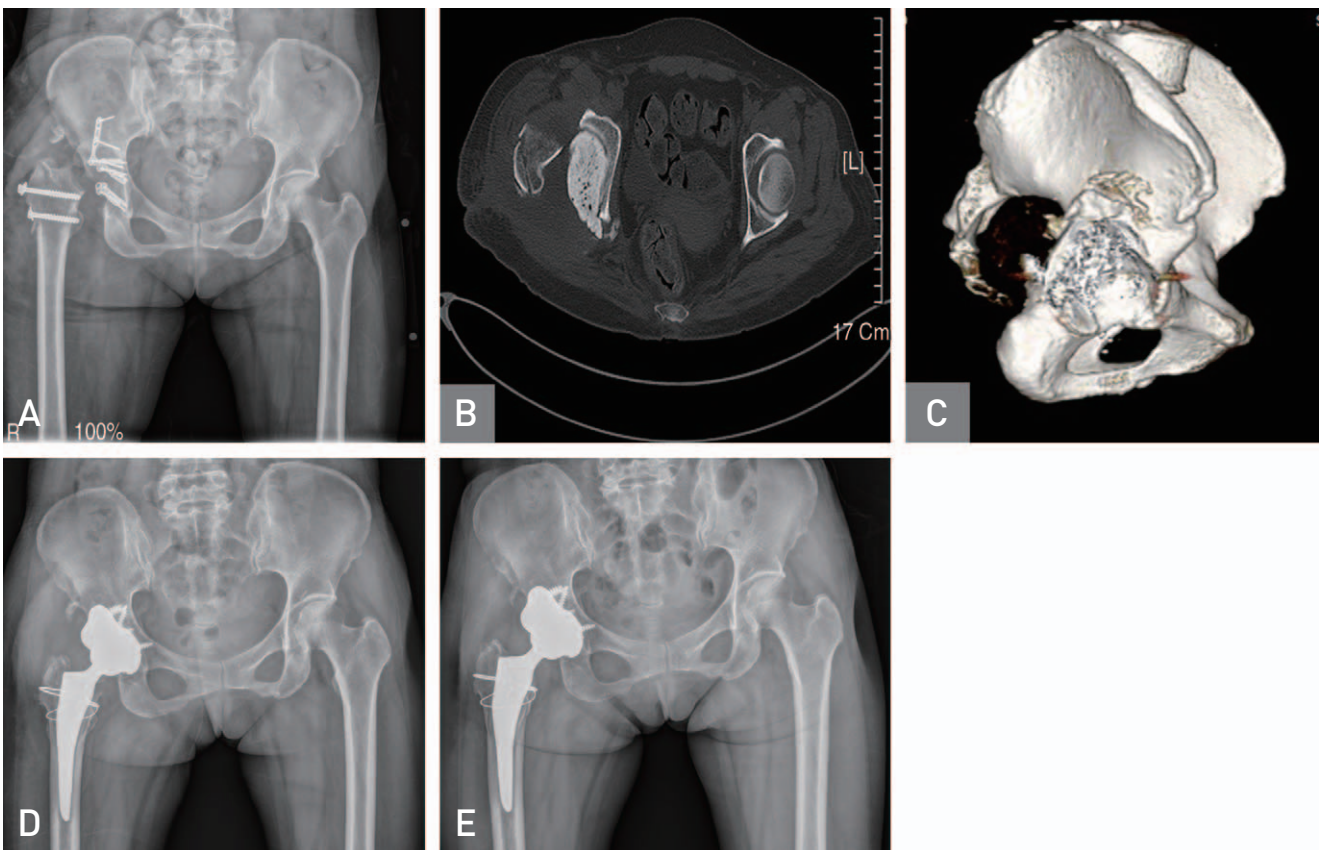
(A) Anteroposterior radiograph of patient after debridement for infection which occurred after open reduction and internal fixation for Pipkin IV fracture dislocation. (B) Preoperative axial computed tomography (CT) scan shows large posterior bone defect of the acetabulum. (C) Preoperative three-dimensional CT scan shows large posterior bone defect of the acetabulum. (D) Immediate postoperative anteroposterior radiograph. (E) One year postoperative radiograph shows well fixed trabecular metal augment and the acetabular cup along with bony ingrowth after total hip arthroplasty.
